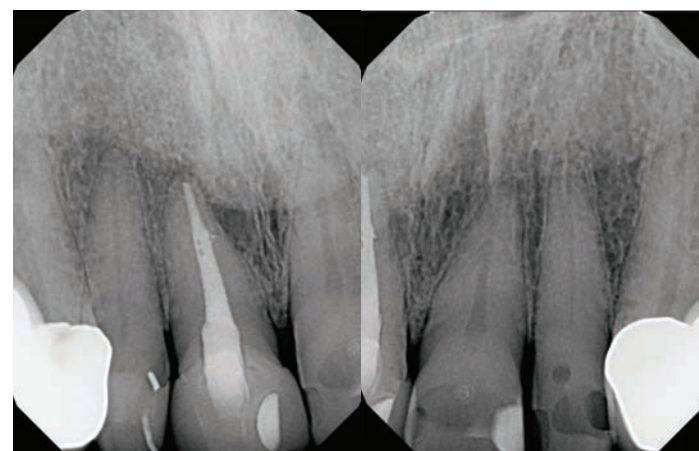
Pre-operative periapical radiograph taken for the anterior teeth, showing tooth # 11 prior to failure.
